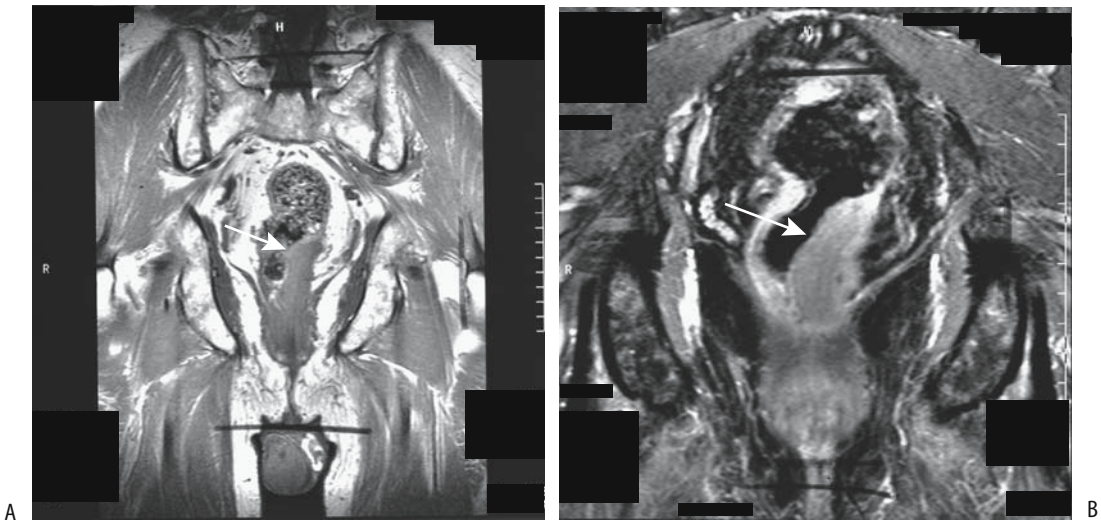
Rectal carcinoma. Precontrast (A) and contrast-enhanced (B) coronal T1-weighted MR images identify a left distal rectal tumor (arrows) invading perirectal fat. (From Burgener FA, Meyers SP, Tan RK, Zaunbauer W. *Differential Diagnosis in Magnetic Resonance Imaging*. Stuttgart: Thieme, 2002, with permission.)
